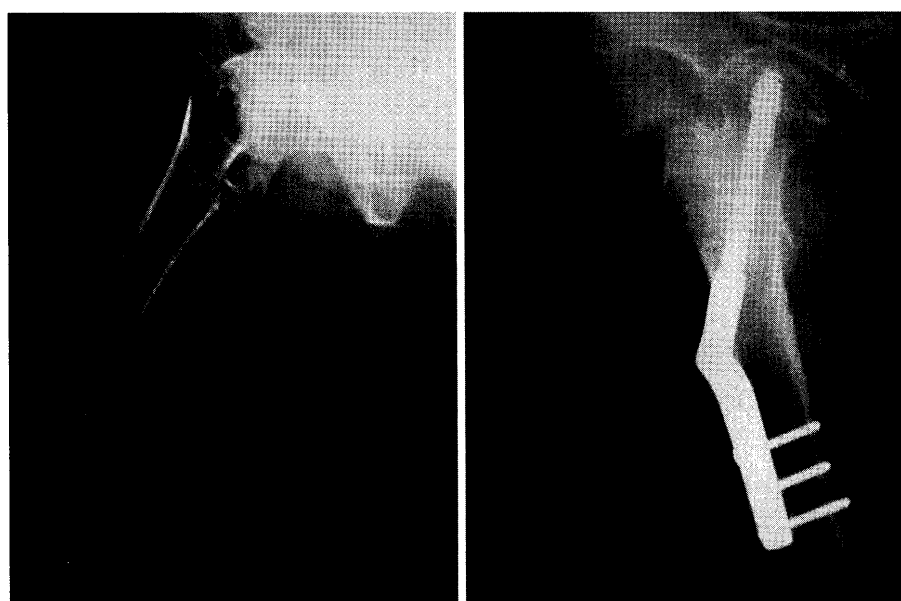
Radiograph 150° CHS
